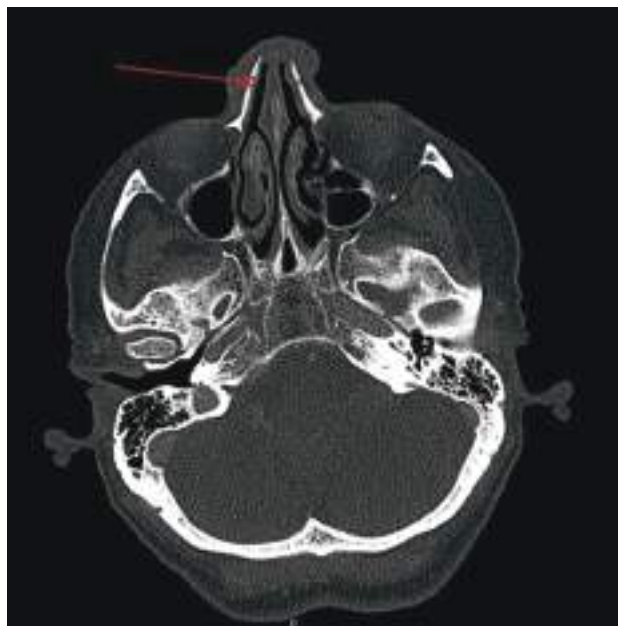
CT scan of the head - tumoral change and involvement of the bony structures of the nose - indicated by an arrow
